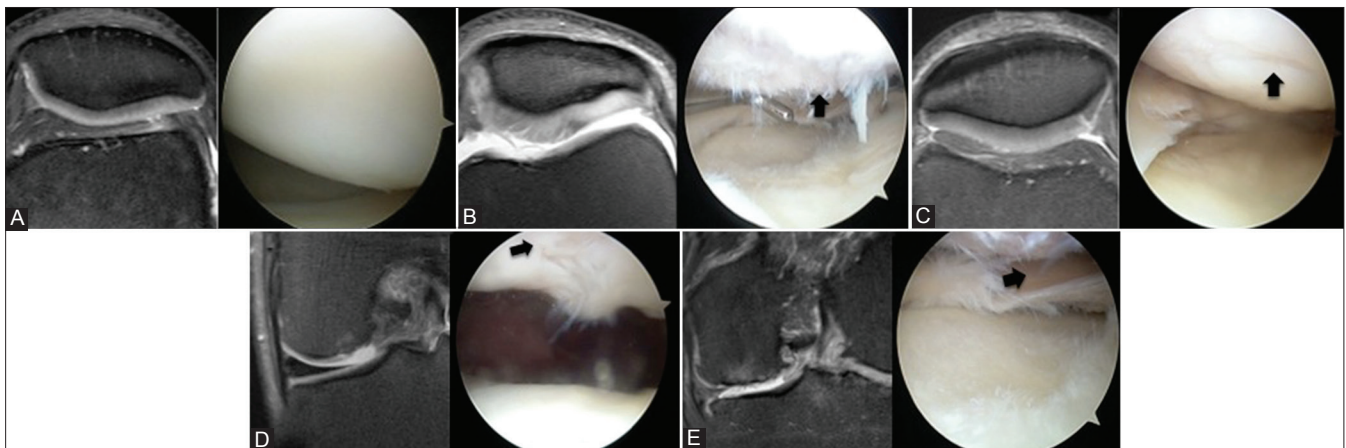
(A-E): MRI images depicting grading of articular cartilage lesions based upon Modified Outerbridge classification. Grade 0 (21A, normal articular cartilage), grade 1 (21B, chondral surface fibrillation), grade 2 (21C, partial thickness chondral lesion), grade 3 (21D, full thickness cartilage lesion reaching the bone), grade 4 (21E, full thickness cartilage lesion exposing the subchondral bone)
